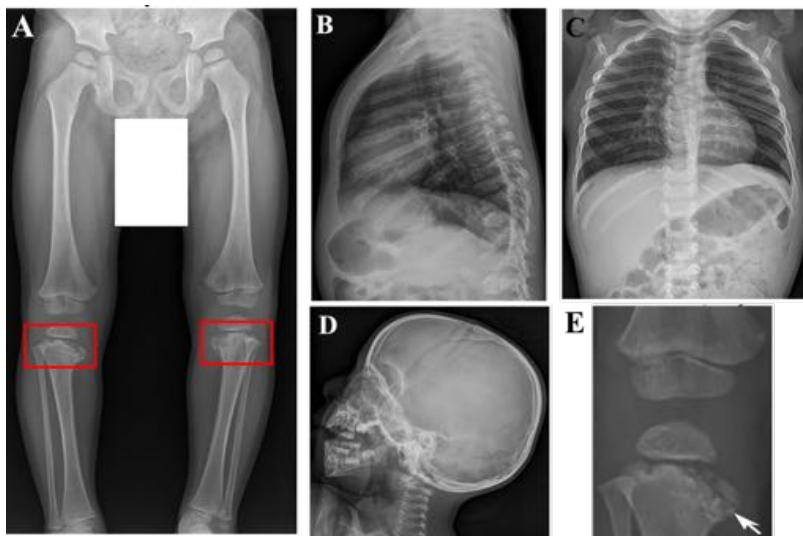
Radiographs of patient with Sutcliffe-type SMD. X-rays were taken of an affected patient at 2.8 years old. (A) Metaphyseal abnormalities and corner fractures are shown in red boxes. (B-C) Flattened vertebral bodies. (D) Flat facial profile. (E) Arrow points to corner fractures.
